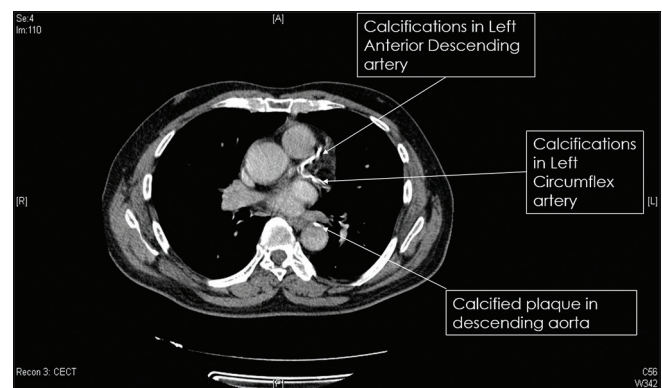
Chest CT scan showing coronary artery calcifications in left anterior descending and left circumflex artery. Also seen are the calcified plaques in the descending aorta
